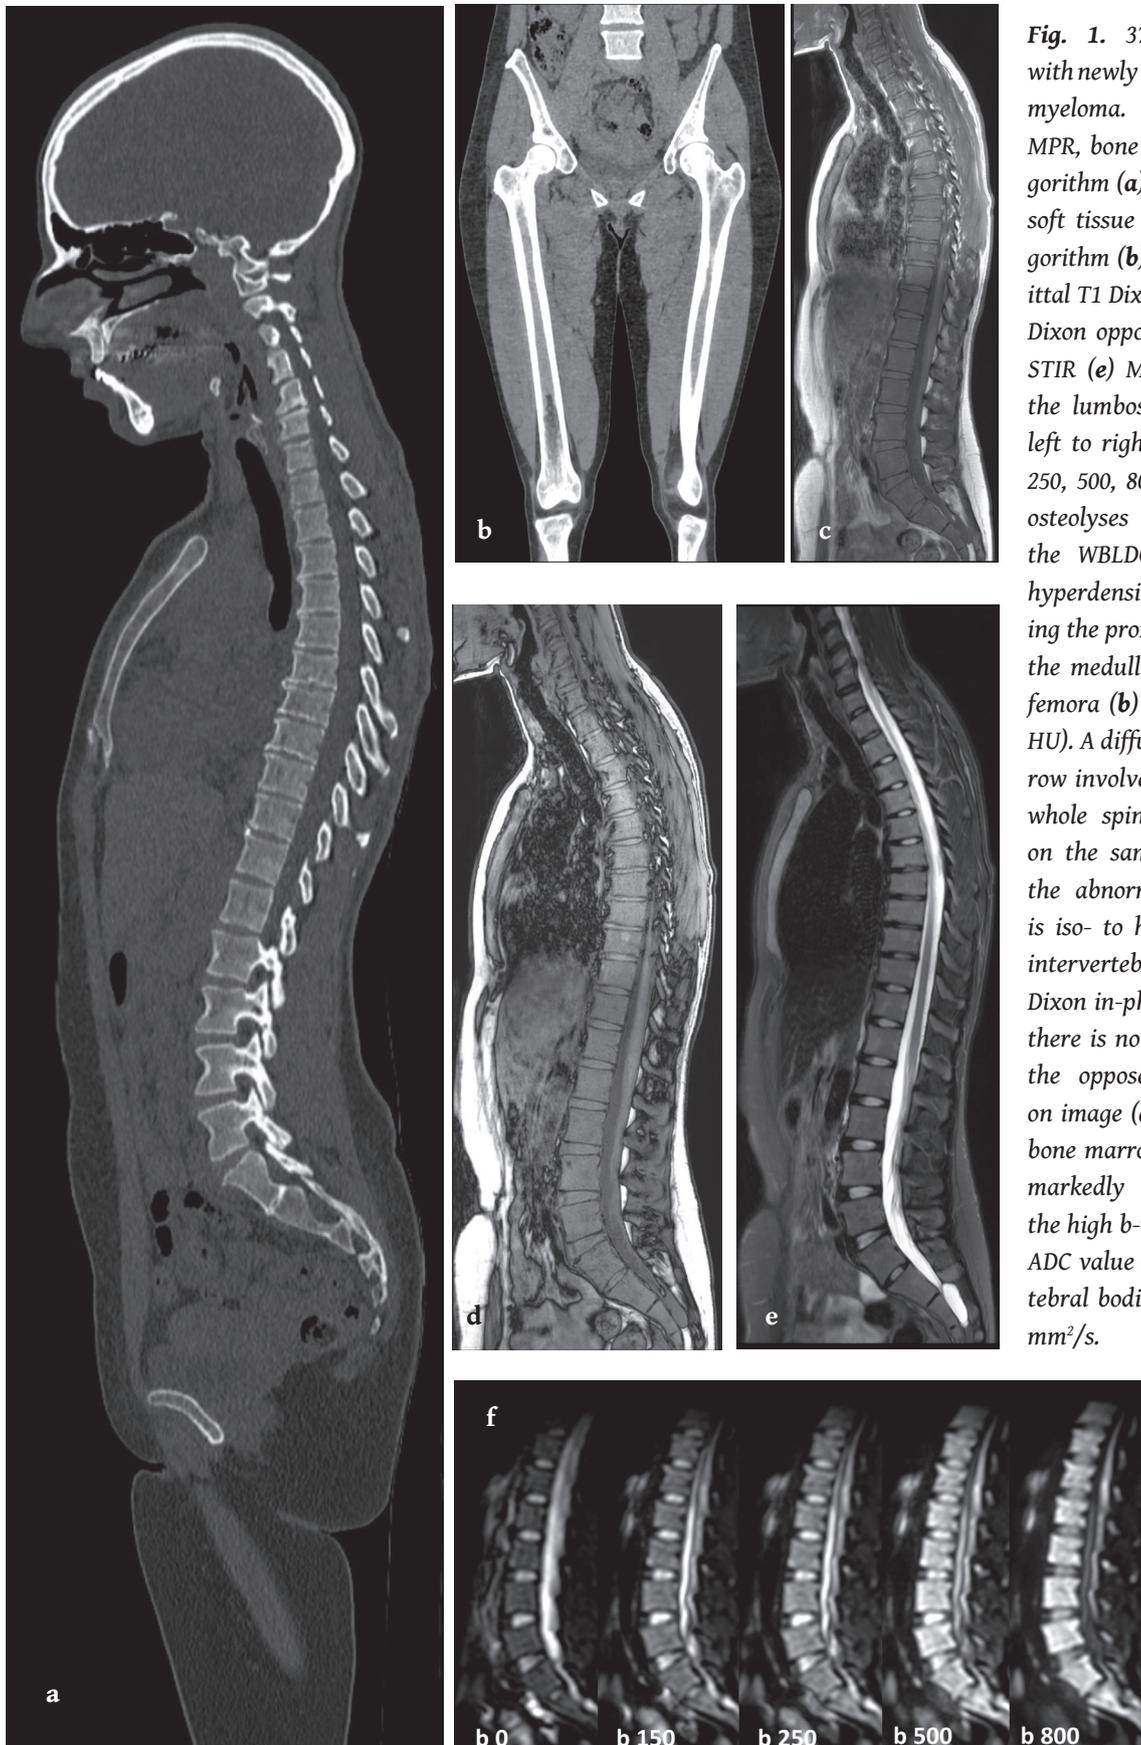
37-year-old woman with newly diagnosed multiple myeloma. WBLDCT, sagittal MPR, bone reconstruction algorithm (a) and coronal MPR, soft tissue reconstruction algorithm (b). Whole spine sagittal T1 Dixon in-phase (c), T1 Dixon opposed-phase (d) and STIR (e) MR images. DWI of the lumbosacral spine (from left to right: b values 0, 150, 250, 500, 800 s/mm²) (f). No osteolyses were present on the WBLDCT study. Diffuse hyperdensities are shown filling the proximal two thirds of the medullary cavity of both femora (b) (mean density: 90 HU). A diffuse pattern of marrow involvement is shown on whole spine MRI performed on the same day. Note that the abnormal bone marrow is iso- to hypointense to the intervertebral discs on the T1 Dixon in-phase image (c) and there is no signal dropout on the opposed-phase T1 Dixon image (d). On DWI (f), the bone marrow is diffusely and markedly hyperintense on the high b-value image. Mean ADC value of the lumbar vertebral bodies was 0.812×10^{-3} mm²/s.
